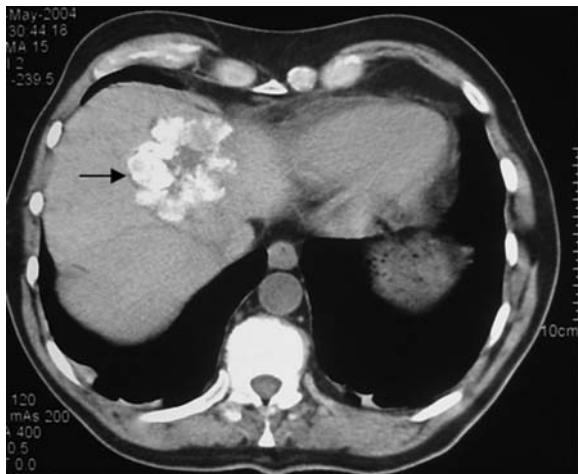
Axial, nonenhanced CT of a patient with HCC (same as in Figs. 10.1 and 10.4) obtained one day following TACE, shows the lesion retaining the radio-opaque Lipiodol (arrow) in its most vascular regions. The retention of Lipiodol – and consequently chemotherapy since the two are mixed – can persist for weeks after TACE and correlates with tumor necrosis
